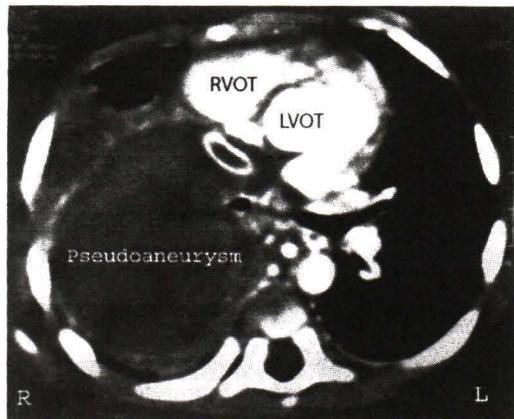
A pseudoaneurysmal mass, measuring 6 x 9 cm, occupies the upper right chest cavity on CT scan of the chest. RVOT = right ventricular outflow tract of the heart; LVOT = left ventricular outflow tract of the heart.
